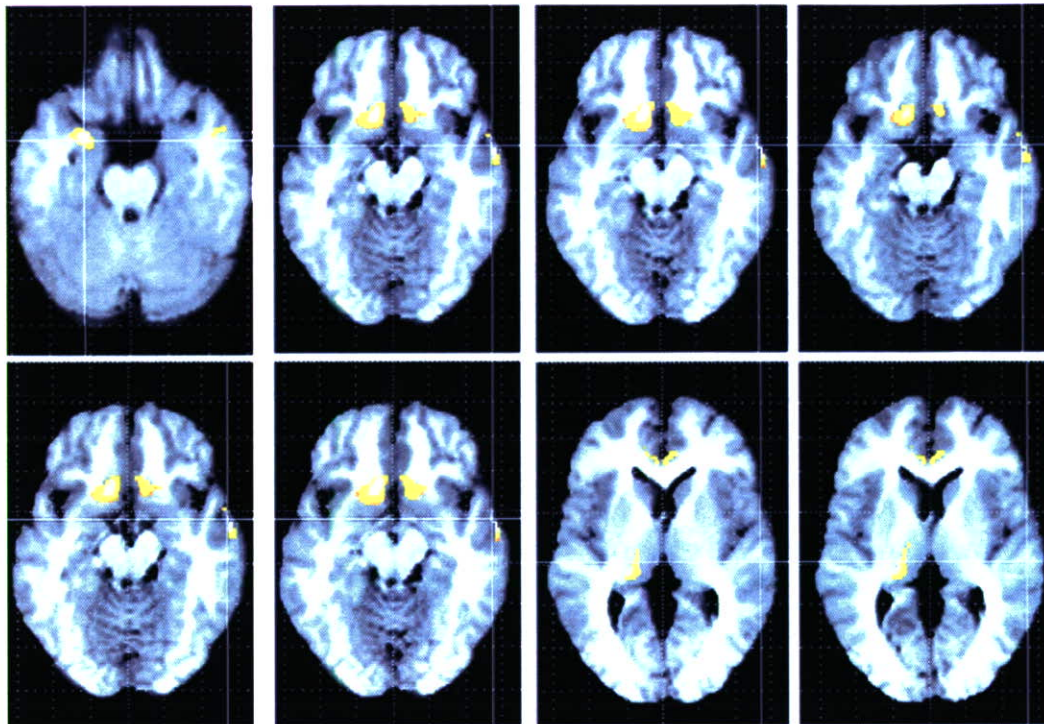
The effects of the Val158Met polymorphism of the COMT gene on brain morphology in schizophrenics. The SPM $\{t\}$ is displayed onto axial T_1 -weighted MR images. The schizophrenics homozygous for the Val-COMT allele ($n = 19$) showed a significant reduction of volumes in the left parahippocampal gyrus, amygdala-uncus, ACC, left thalamus and the right MTG when compared to patients who carried the Met-COMT allele ($n = 28$).
